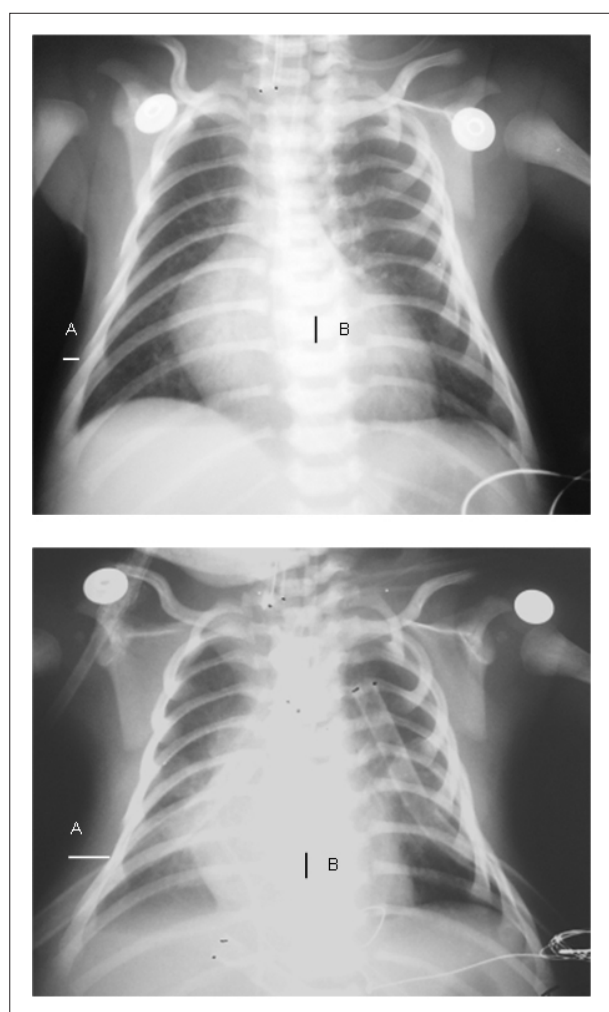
Delimitation of parameters for radiologic index. In A, the thickness of the subcutaneous tissue is measured and, in B, the vertebral height, which is utilized as index factor, is measured. Preoperative interstitial thickness is compared to that of the postoperative period. These are radiographs of a patient submitted to Jatene procedure, and it is possible to observe a great increase in the thickness of soft tissues in the first postoperative hour.
